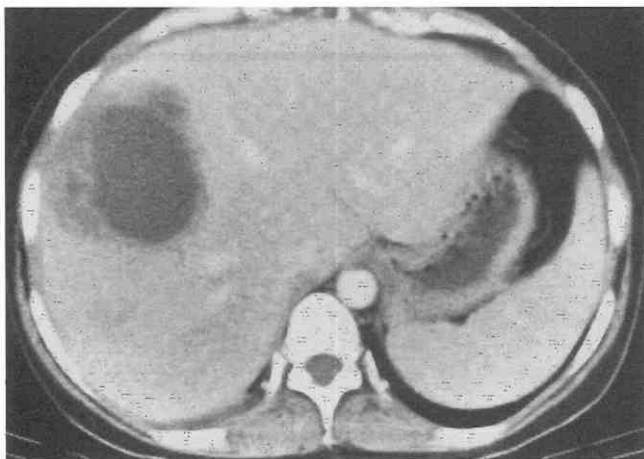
Pyogenic abscess. Contrast-enhanced CT scan demonstrates the "cluster" sign with two small lesions adjacent to the large central cavity.
